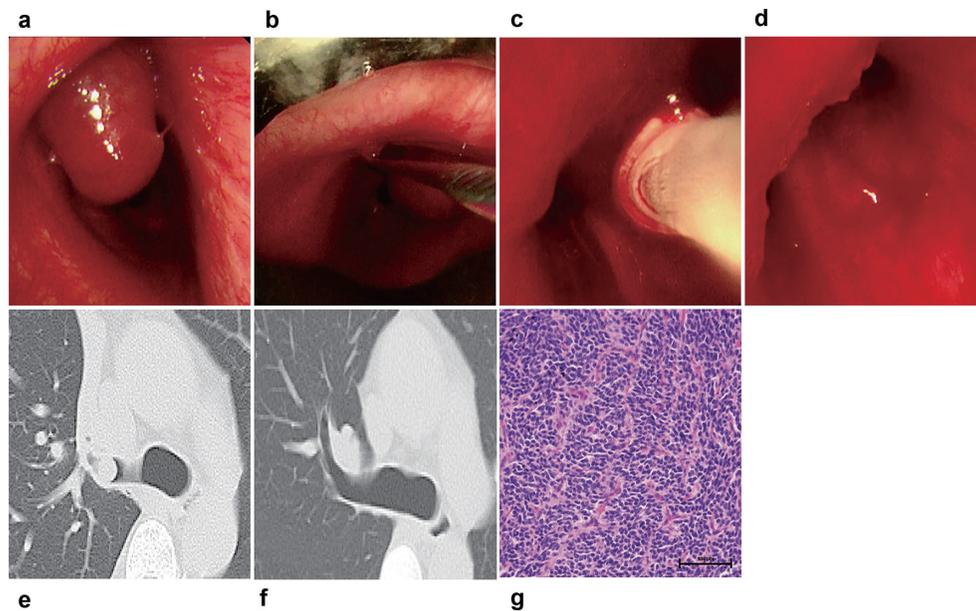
Bronchoscopic, computed tomographic (CT) and pathologic findings in patient No. 3.
